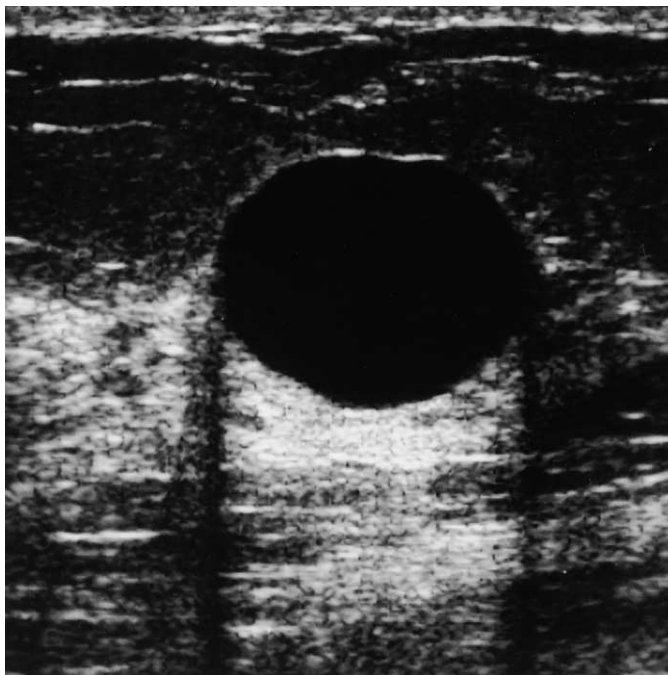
Sonography of a simple cyst. Characteristics of a simply cyst include a thin wall, no internal echoes, round/oval shape, and posterior acoustic enhancement.
